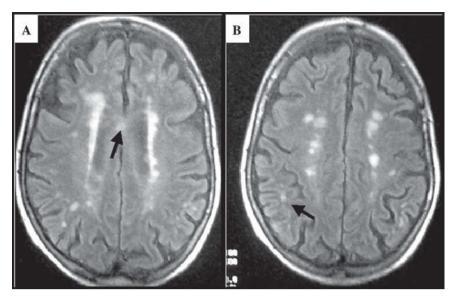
MRI of the head (FLAIR sequence) of the eldest patient in the series (76 years): several hyperintense areas are seen in the white matter, many of which are located periventricularly and with the largest axis perpendicular to the lateral ventricles the arrows point to other lesions in the corpus callosum (A) and juxtacortical lesions (B).
